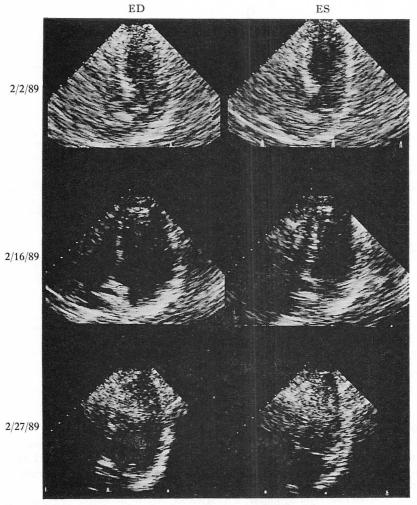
Serial two-dimensional echocardiograms of Patient 1.
